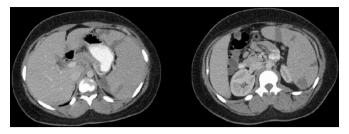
The repeated contrast-enhanced CT scan of the abdomen and pelvis showing increases in the number and size of splenic infarcts compared with the previous contrast-enhanced CT scan.
